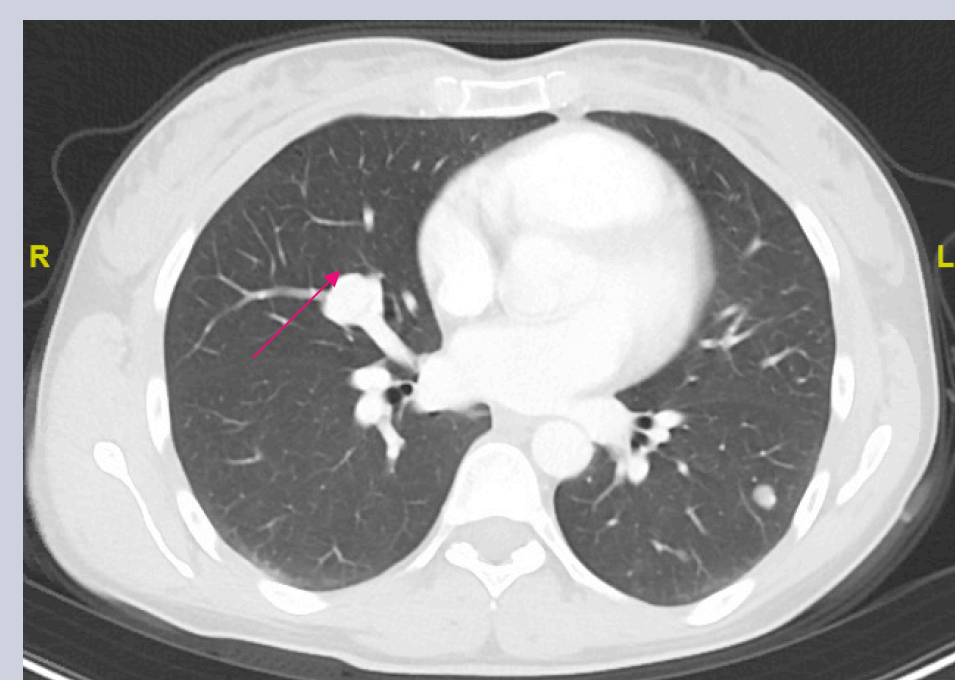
CT Chest at time of presentation demonstrating lung nodules (arrow)
